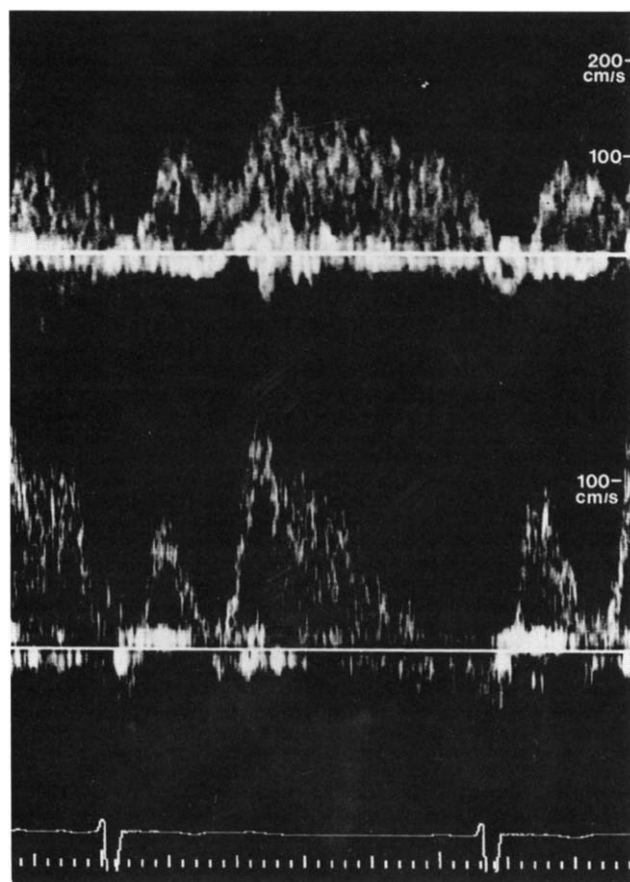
Patient 1: Pulsed Doppler signal at the site of pulmonary venous pathway obstruction. Upper panel. Before balloon dilation, maximal flow velocity is elevated and velocity remains high throughout diastole. Lower panel. After dilation, maximal flow velocity is diminished and flow is no longer continuous throughout diastole.
